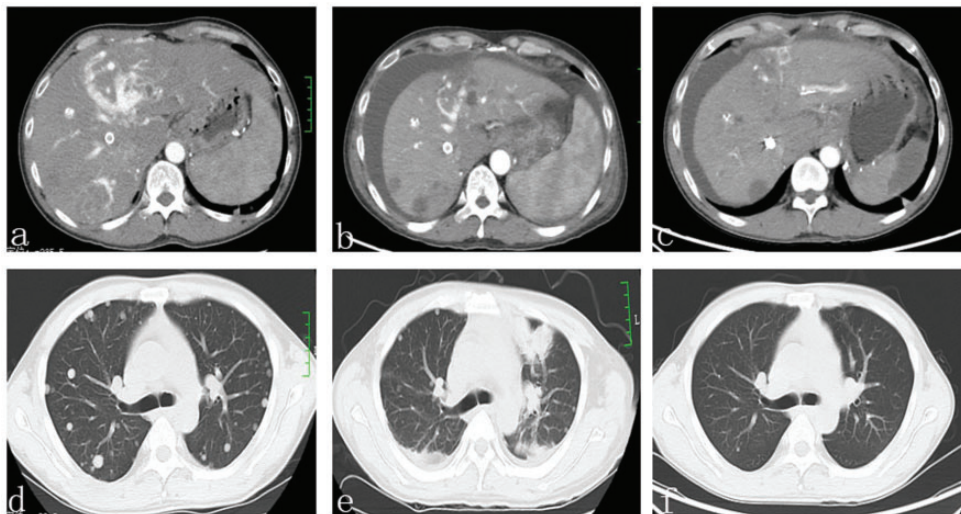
Contrast-enhanced CT before and after camrelizumab therapy. CT images before treatment with camrelizumab (a, d) and after two cycles (b, e) and four cycles (c, f) of camrelizumab (200 mg administered intravenously over 30 minutes once every 2 weeks in a 4-week cycle). A CT image shows hepatocellular carcinoma with APS and multiple bilateral lung metastases (a, d). All lung lesions rapidly responded to camrelizumab (b, e), and after four cycles, most lesions were diminished in size or had disappeared. Liver masses remained stable, and APS was relieved (c, f). CT, computed tomography; APS, arteriportal shunt.
